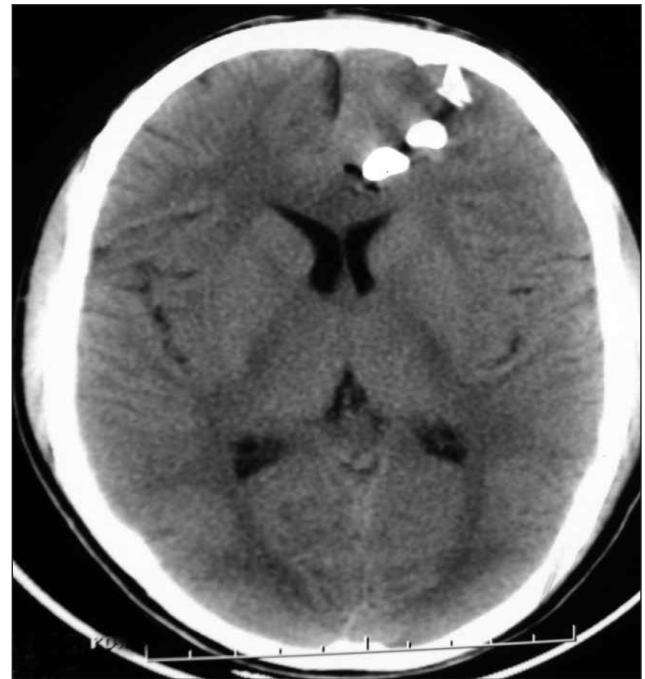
Preoperative CT Head showing three globular hyperdense objects in left frontal region.
